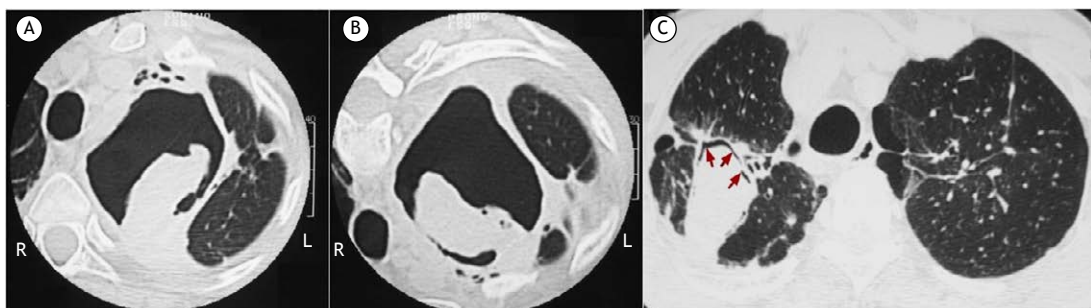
Axial CT scans with lung window settings acquired with the patient in the supine (A) and prone (B) positions, showing mobility of the fungus ball within a cavity in the left upper lobe. In C, an air crescent sign (arrows) within a cavity containing a fungus ball in the right upper lobe.
